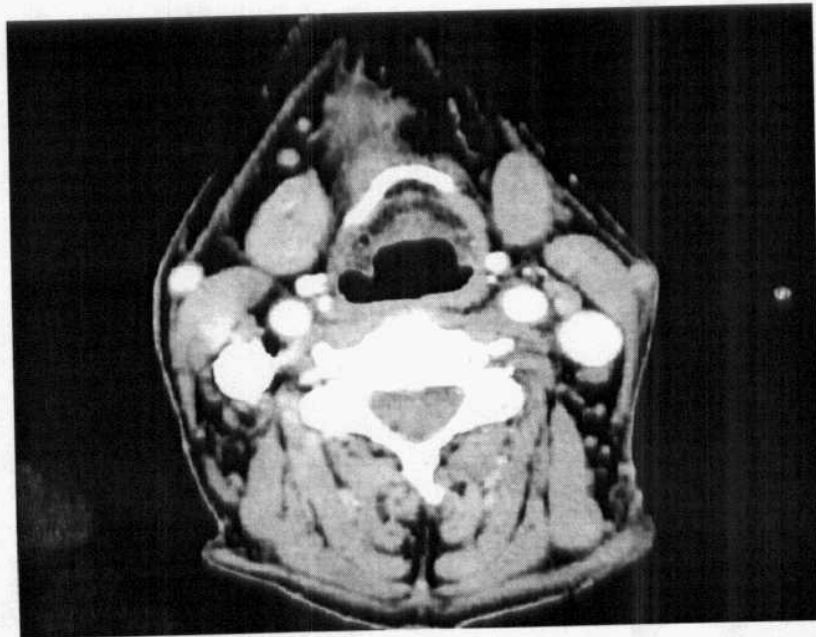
axial CT cuts at carotid bifurcation with 1.25 mm interval.. Maximum vascular enhancement is noted. Quoted from (Rubin et al., 2000)
